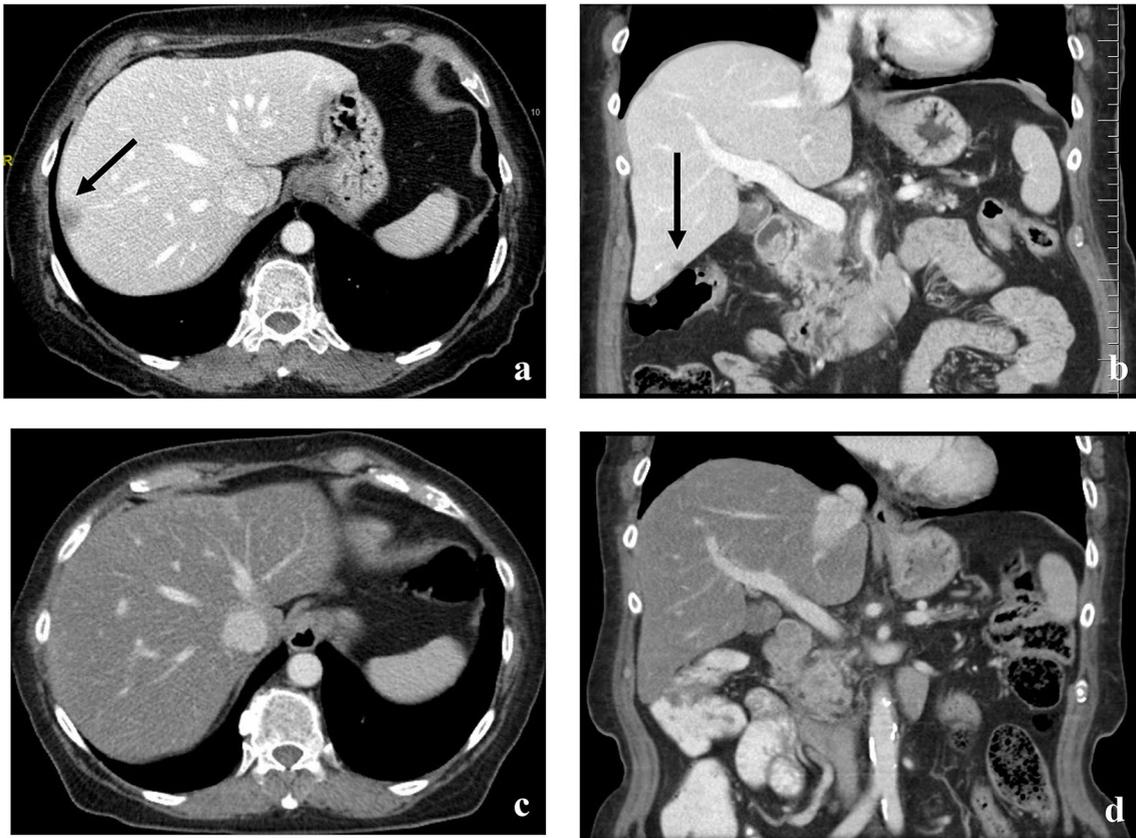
A 68-year-old female with stage IV pancreatic cancer treated with FOLFIRINOX. Pre-treatment contrast-enhanced CT images (a, b) show normal liver parenchyma with a focal hypodense lesion (arrows) compatible with hepatic metastatic disease. Post-treatment images (c, d) demonstrate interval development of diffuse hepatic
